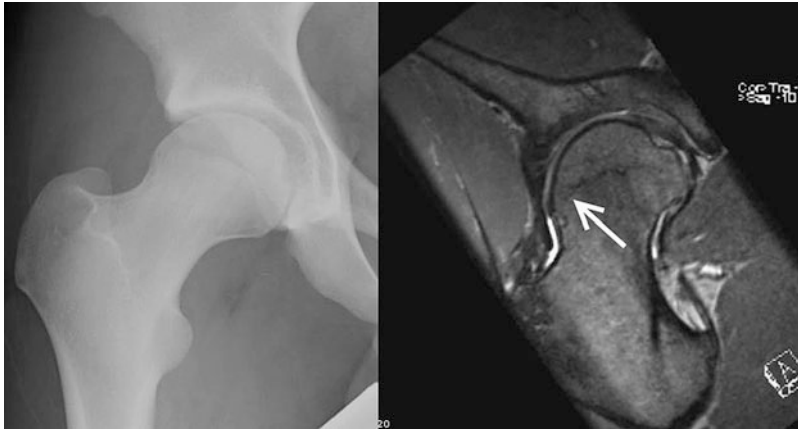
Physical extension seen on the MRI scan of a patient with cam impingement. Deformity is distinctly different from a SCFE
